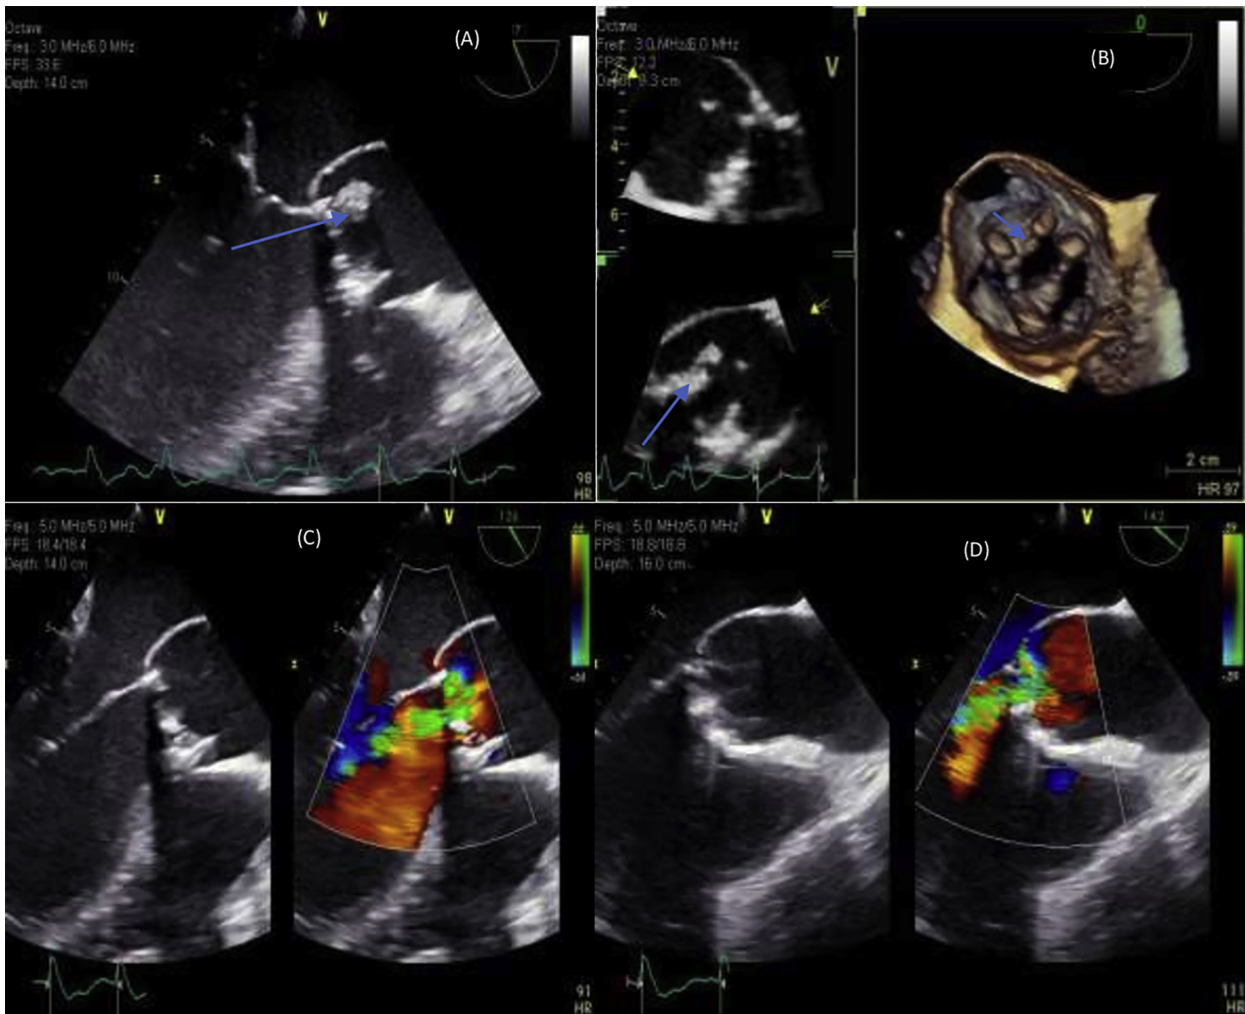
Transesophageal echocardiography performed in February 2020 showing markedly thickened leaflets with a partial disinsertion of the NC leaflet on two-dimensional and three-dimensional (*blue arrow*) imaging (A, B), resulting in severe intraprosthetic regurgitation (C, D).
